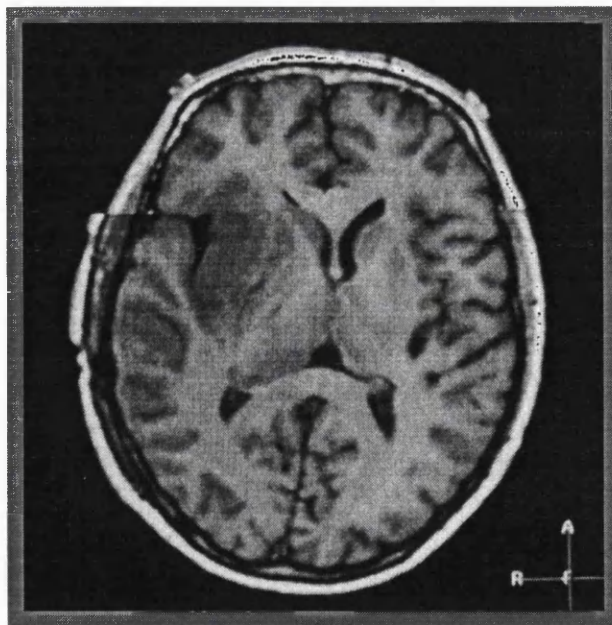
The moving curtain overlay of fused pre- and post-operative MRI scans. Note how well the cerebral structures and skull match and that post-operative swelling has distorted the skin in the lower image.
